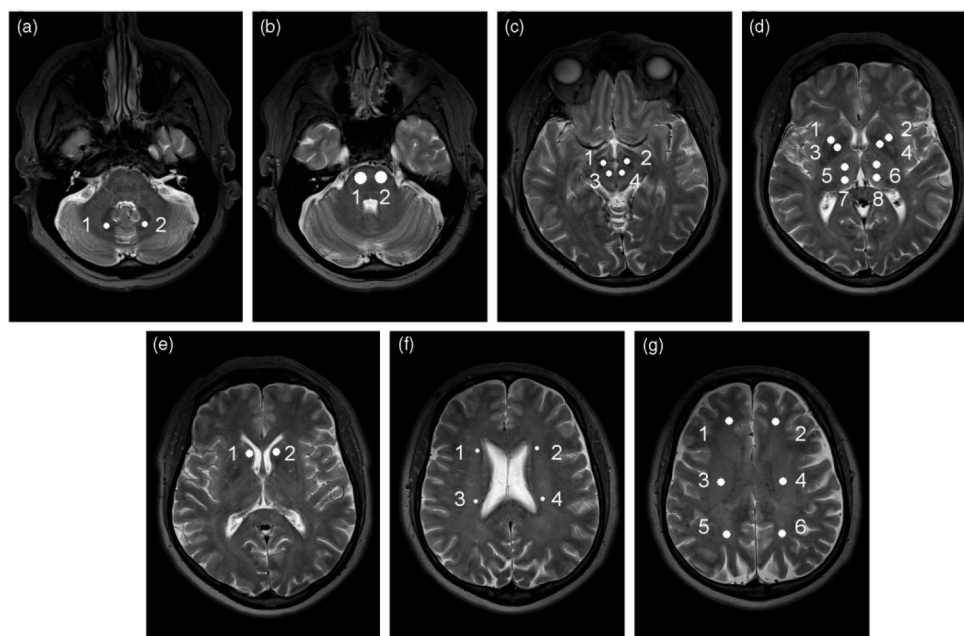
Image levels. Visualization of MR image levels (a–g) and regions of interest. The regions of interest are marked with numbers and specified in Table 3.
